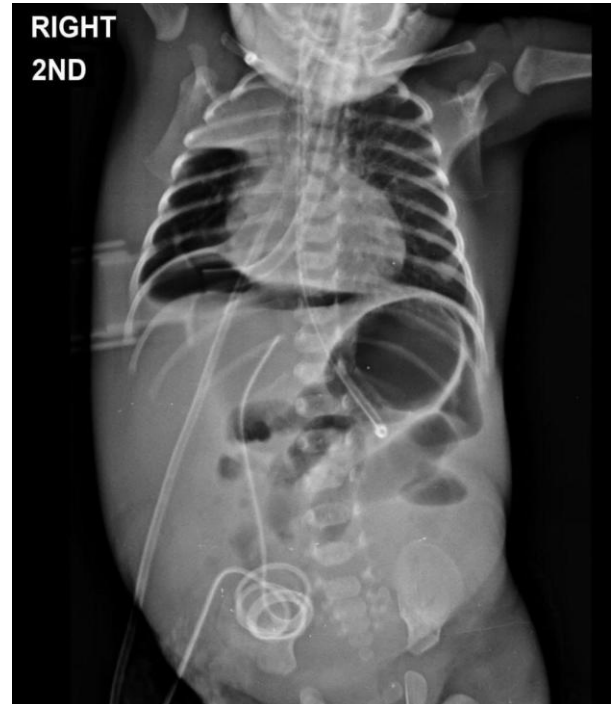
Erect Radiograph of Abdomen Showing Free Subdiaphragmatic Air, Multiple Air Fluid Levels
